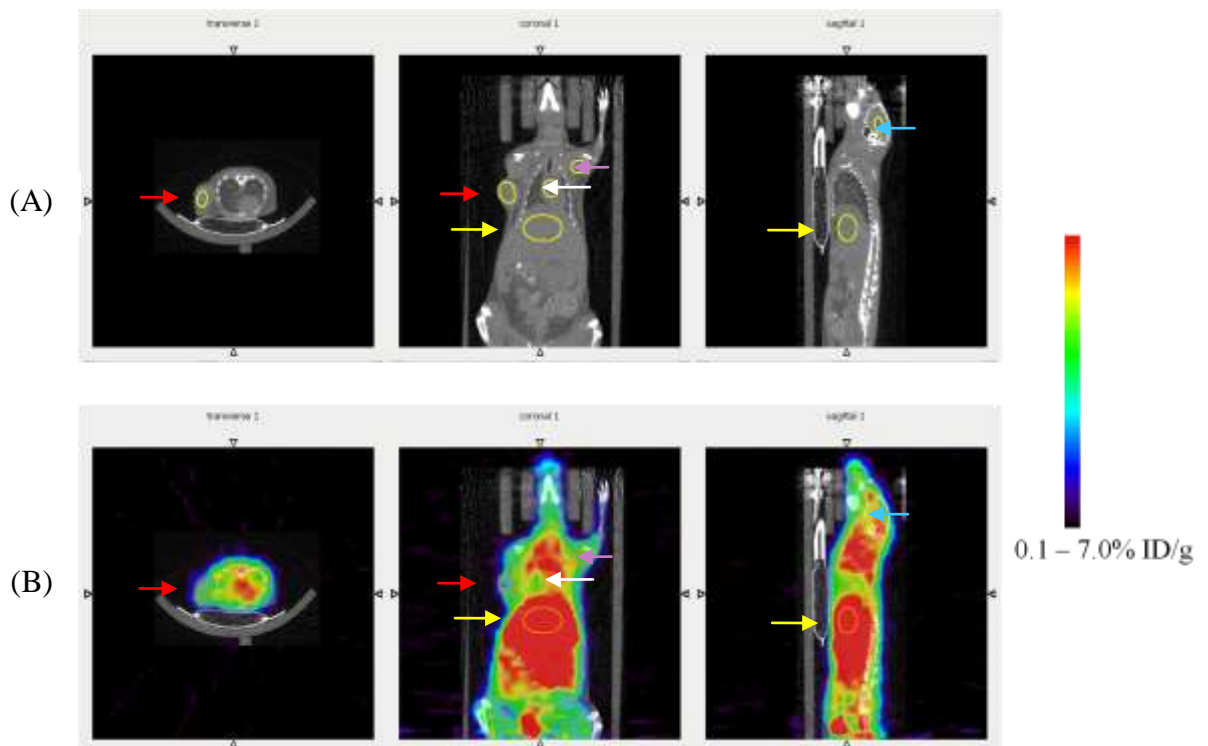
Dynamic PET image 16-18 minute pi: ROIs for tumour (transverse and coronal view, red arrow), heart (coronal view, white arrow), liver (coronal and sagittal views, yellow arrow) and muscle (coronal view, purple arrow). (A) CT image (B) PET/CT image. PET colour indicating 0.1-7.0% ID/g
